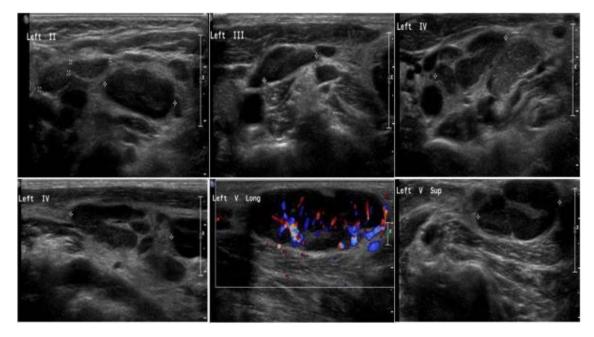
Routine neck ultrasonography shows multiple enlarged lymph nodes along the left internal jugular chain (level II–V). The largest node at level V measures 3.8 cm and shows perinodal infiltration and increased vascularity. Well-preserved fatty hilum of multiple enlarged nodes is seen. Several small (less than 1 cm diameter) nodes are seen in the right internal jugular chain (level II–V). No perinodal infiltrations, intranodal necrosis, or abscesses are seen
